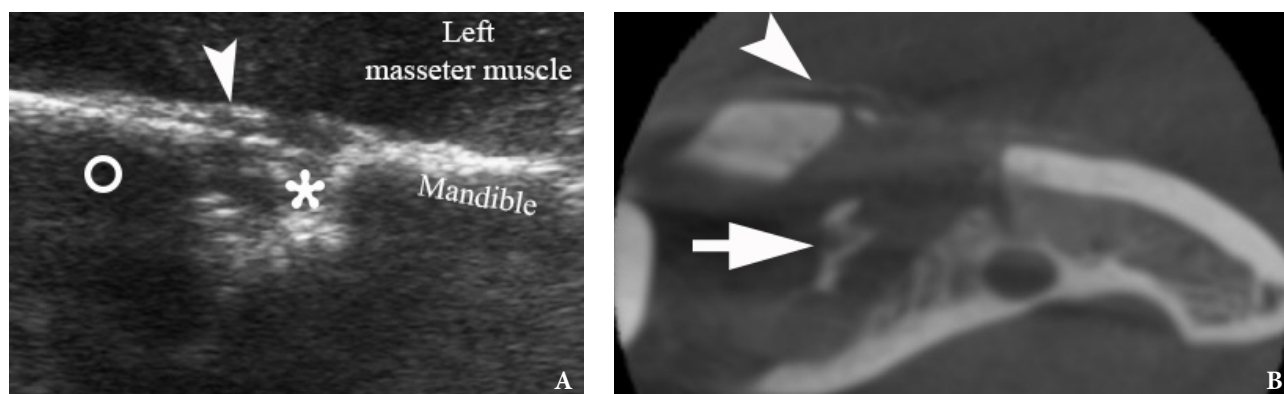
Left side. Comparing periosteal reaction on (A) gray-scale sonogram and (B) axial CBCT scan at the same location but on different terms of the course of osteomyelitis (USG – on day 28 after tooth extraction and CBCT – on day 51 after tooth extraction). Periosteal reaction (*arrowhead*) is visualized as thickening and elevation of the periosteum from the underlying lateral cortical bone of the ramus. Intraosseous defect in ramus is indicated by *asterisk*. A *circle* labels the artifact of acoustic shadowing posteriorly to the lateral surface of the mandibular ramus. Bone defect of the cortical bone is a place via which the purulent content spread through the periosteum and between fibers of the masseter muscle. *Arrow* labels sequestrum.
